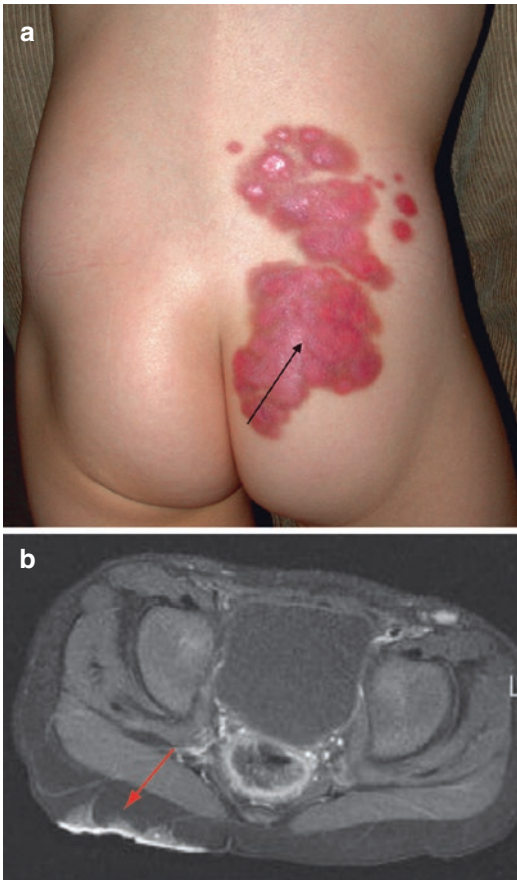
Kaposiform hemangioendothelioma without KMP in a 3-year-old boy. (a) Tumor at the lumbosacral region. (b) Infiltrative growth in the subcutaneous region confirmed by MRI
